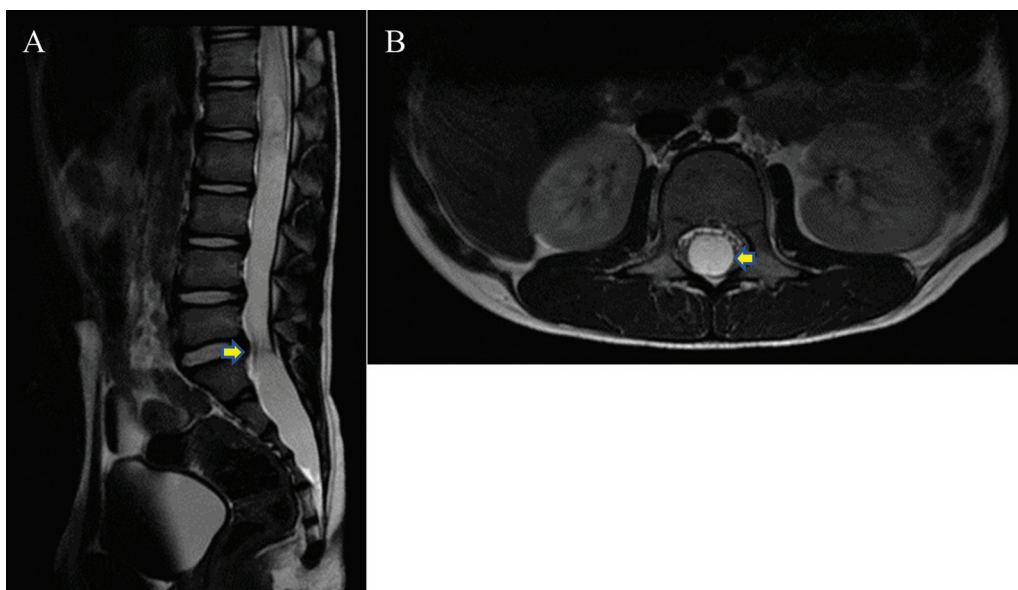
T2-weighted magnetic resonance imaging (sagittal [A] and axial [B]) showing two intradural spinal arachnoid cysts. The extent is T12-L5 for the first and S1-S5 for the second.
